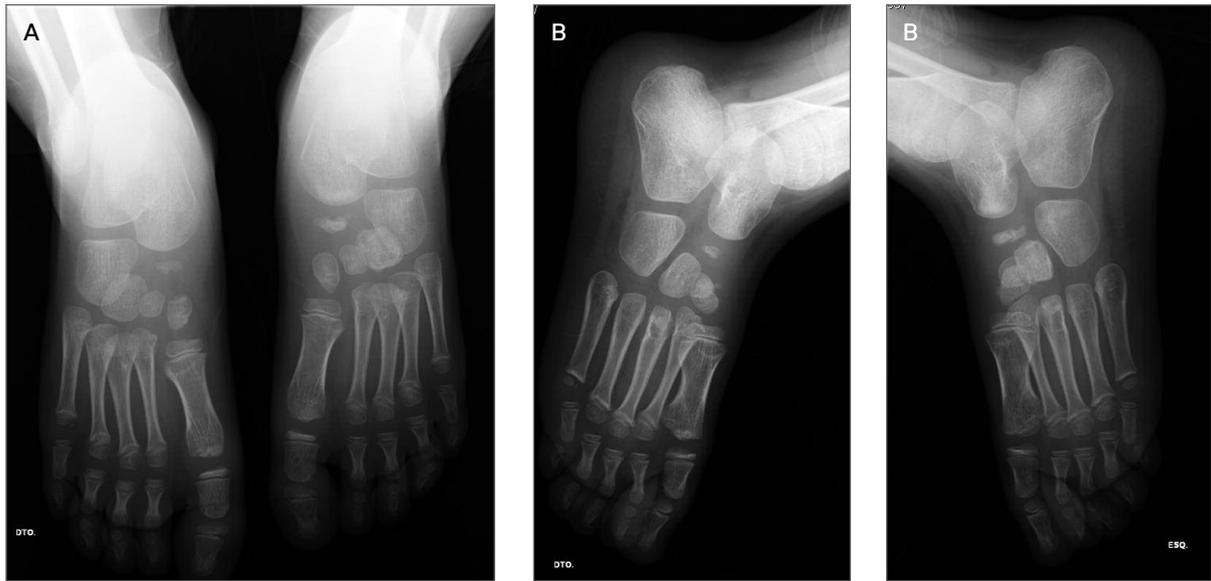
Antero-posterior (a) and lateral (b) feet radiographs showing sclerosis, collapse and irregularity of both navicular bones
